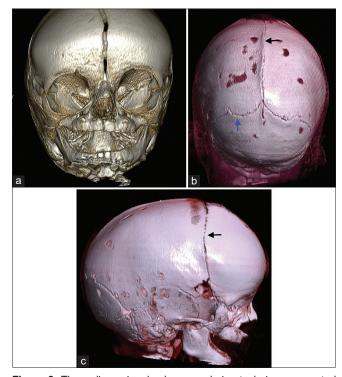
Three-dimensional volume-rendering technique computed tomography image showing (a) fused sagittal sutures; (b) fusion of sagittal suture (black arrow) and decreased space of the lambdoid suture (blue arrow); (c) dolichocephalic head with focal fusion of the right coronal suture (black arrow) and reduced space of rest of the coronal suture
